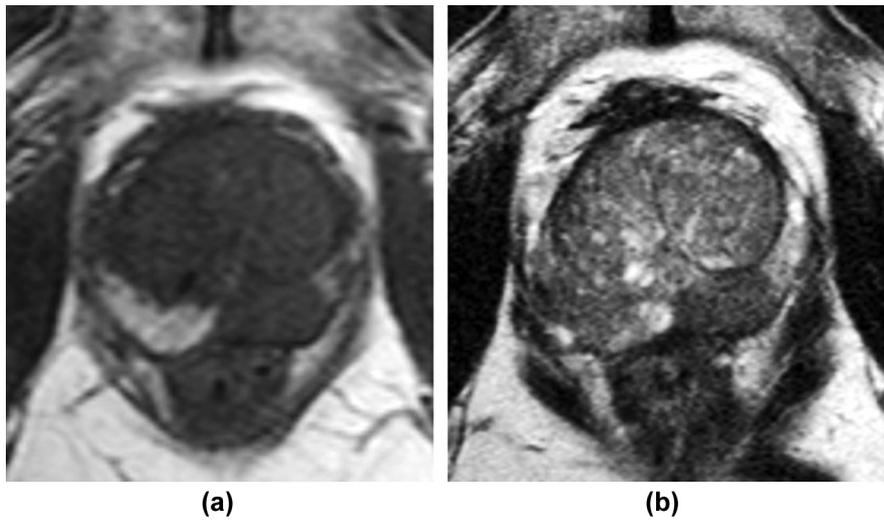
Haemorrhage exclusion sign. TRUS biopsy demonstrates a Gleason 4+4 lesion in left mid PZ. MRI performed post-biopsy shows haemorrhage in the right PZ on T1WI (a) with ill-defined matching low T2 signal (b). Tumour in the left mid PZ demonstrates more focal low T2 signal (a) and “excludes” haemorrhage, which surrounds and outlines the lesion on T1WI (a).
